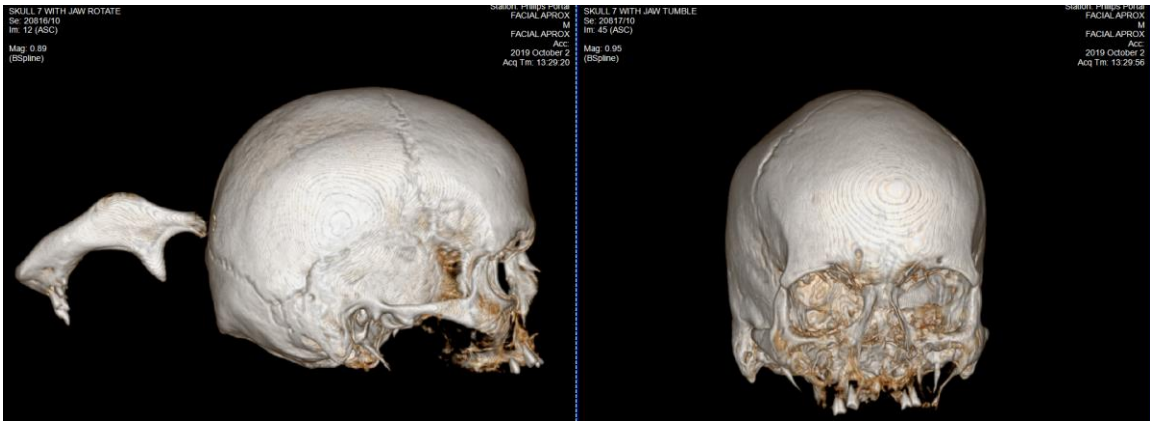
CT scan of skull 7. Left lateral and anterior views.
